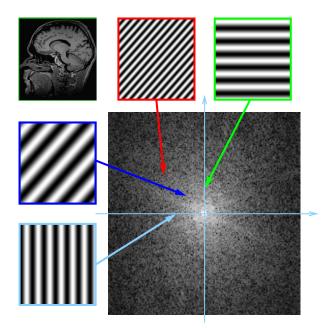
The structure of k-space which is a  $(k_x, k_y)$ -coordinate space where each point correspond to a particular phase roll pattern, here indicated by color coded phase images (phase angle mapped to color). The background color in the large image indicates the measured RF signals (Fourier coefficients  $W(\mathbf{k})$ ) for a particular patient (corner) after the phase roll patterns are refocused one by one using gradients. k-space is a book-keeping tool used to keep track of the phase roll patterns needed to do imaging: We need to measure the MR signal  $W(\mathbf{k})$  for each of the phase roll patterns  $\mathbf{k}$  corresponding to the shown central region of k-space. The more of k-space we cover, the more detailed will the resulting MR image be.
